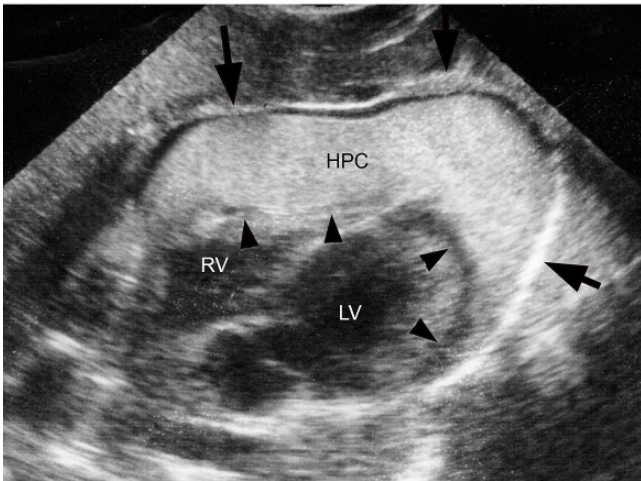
(a) A small circumferential haemopericardium (between arrows). (b) Subxiphoid view of a patient who sustained a cardiac arrest minutes after being struck by a car. The potential space between the visceral (arrowheads) and parietal pericardium (arrows) is filled with organised clot (HPC). There is a thin peripheral layer of unclotted blood. As a result of these ultrasound findings, and because the arrest was witnessed, an open thoracotomy was performed and the haemopericardium was evacuated with return of vital signs and subsequent cardiac repair. The patient survived and was discharged with full neurologic function. Abbreviations as Figure 8.8. Figures © A. J. Dean.
